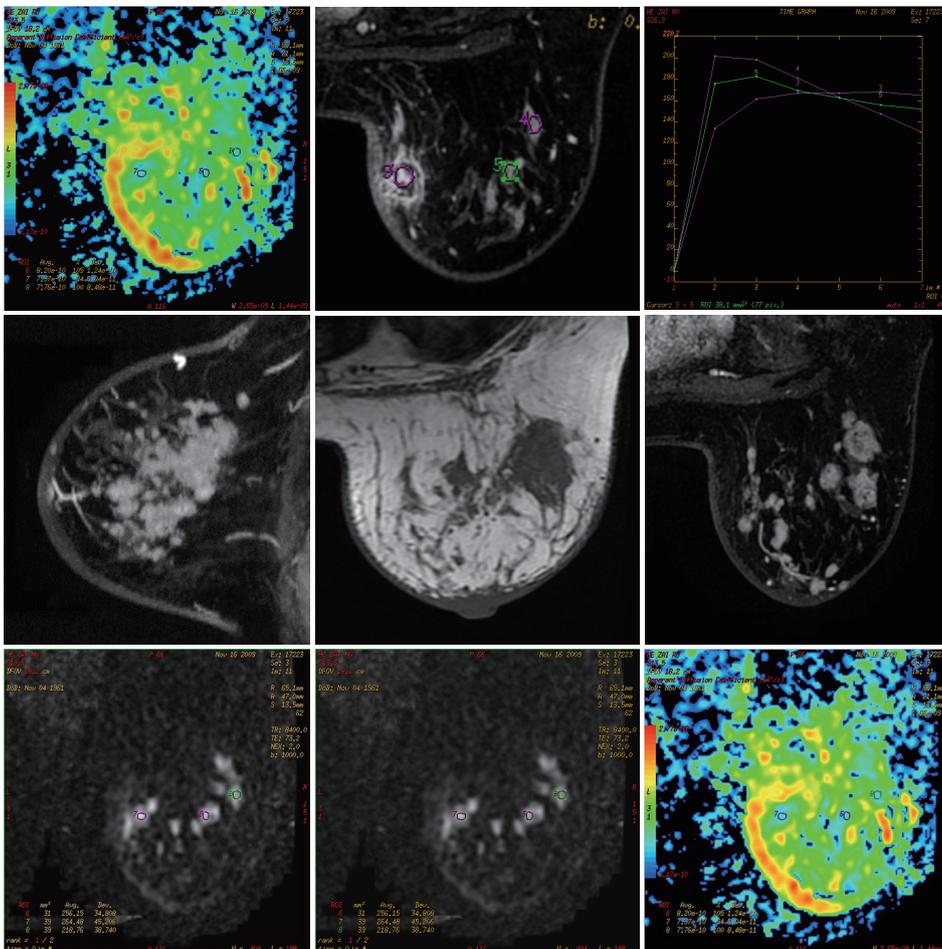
Stripe-like enhancement MRI shows distorted trabecular-like thickening, with glands and adipose tissues within the lesion. B927110.
